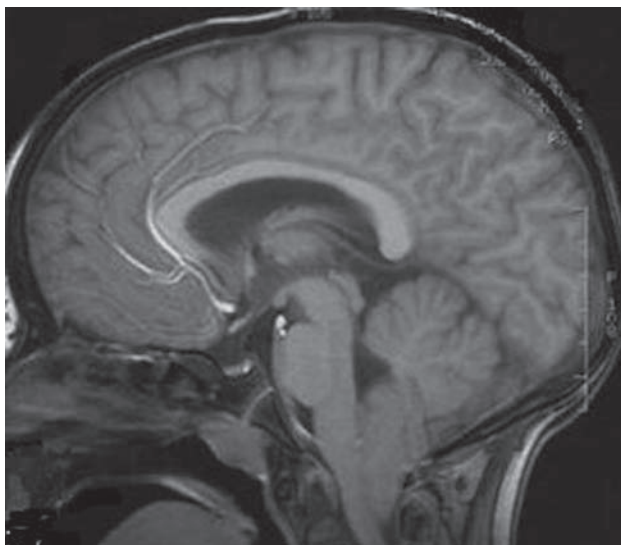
Chiari malformation. Low-hanging, elongated cerebellar tonsils displaced below the level of the foramen magnum on a sagittal T1-weighted MRI.
